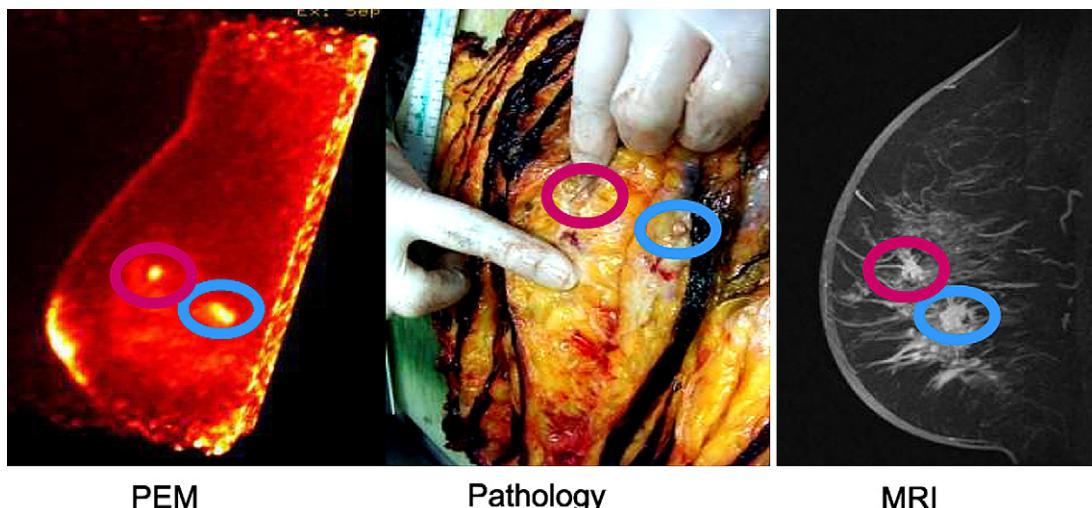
A mass with increased FDG uptake in the left breast of a patient with breast cancer. MRI and PEM found 2 IDC lesions not seen by conventional mammography. Ultrasound identified lesion at 10 o'clock. PEM gave a closer estimate of lesion size. More importantly, PEM interpretation time was significantly faster than MRI acquired at 0.6-mm slice thickness which is an important issue for busy diagnostic imaging facilities. (Courtesy of Naviscan PET Systems, San Diego, CA.)
